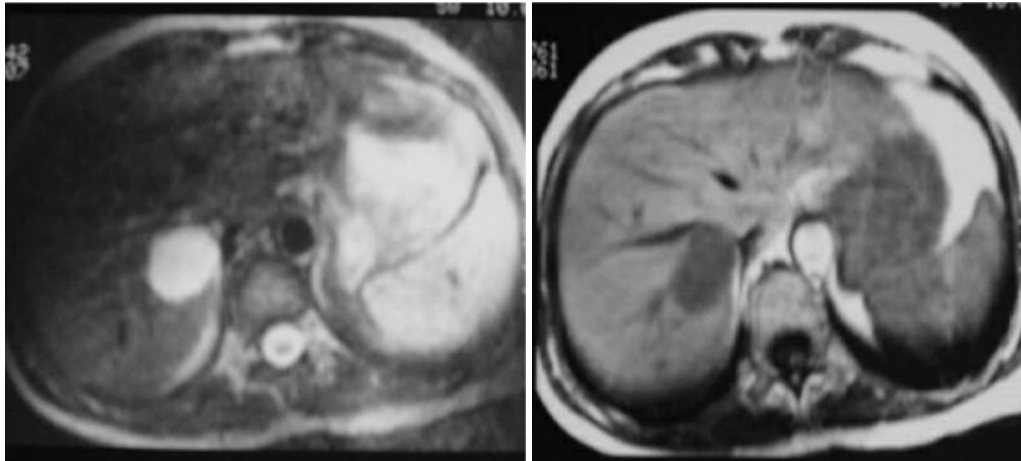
Homogeneous hyperintensity on T2-weighted images: diagnostic of certainty
